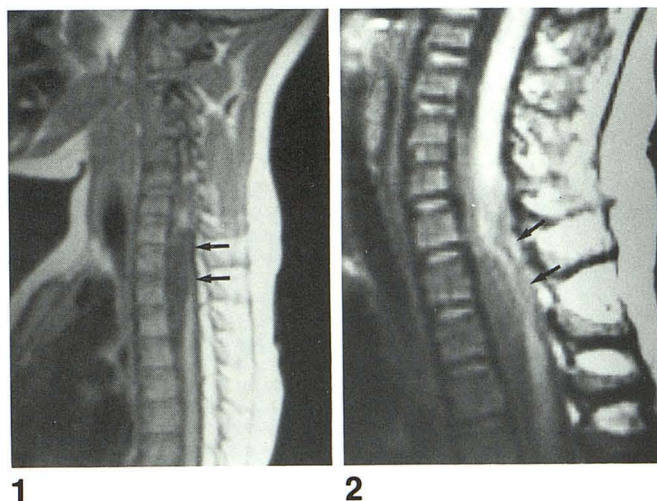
Case 1: Sagittal MR image (700/20; 0.5 T) shows marked atrophy of cord (arrows) extending from C7 to T3. Thoracic spinal cord is normal. No fractures or subluxations are present.
